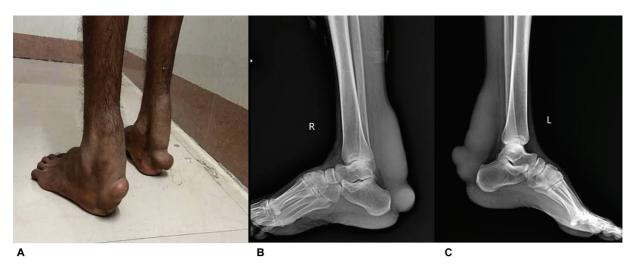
(A) Clinical image shows soft tissue swellings in bilateral lower extremities extending from the lower calf to the posterior regions of the ankle, with bilobed appearance on both sides. Lateral plain radiographs of right (B) and left (C) lower half of legs and ankles show diffusely thickened Achilles tendon with soft tissue mass extending cranially from the lower third of the calf to the insertion site of the Achilles tendon along the expected course of the tendon.
